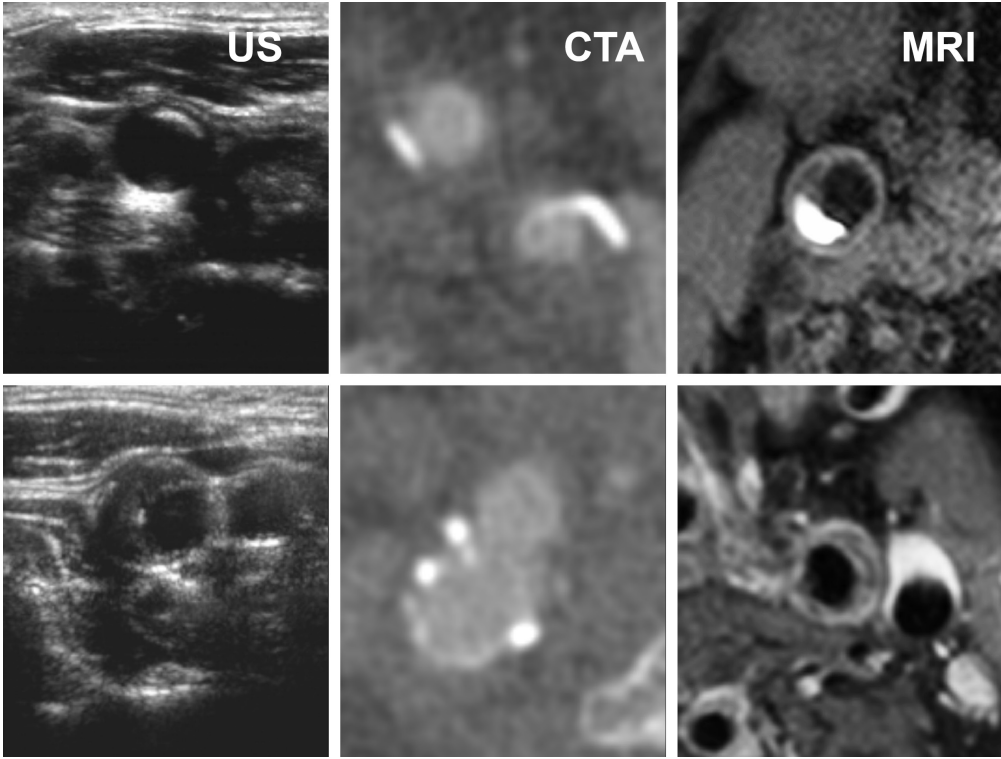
Examples of axial slices of the carotid artery in ultrasound (US), CT-angiography and MRI. The ultrasound images show a plaque with high echogenicity in the top row and low echogenicity in the bottom row. CTA clearly depicts the lumen and calcification. The T1 IR-TFE MRI in the top row has a high-intensity region of intraplaque hemorrhage and a dark calcification spot. The postcontrast T1w MRI in the bottom row shows a hypointense region in the center of the thickened wall due to a lipid-rich necrotic core.
